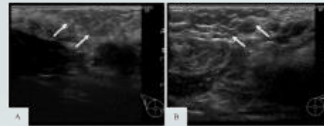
Ultrasonography of the both axillary areas. (A) Right side, (B) Left side. (A, B) Ultrasonography of both sides of anterior axillary areas revealed heterotopic, but apparently normal breast structures (arrows).
